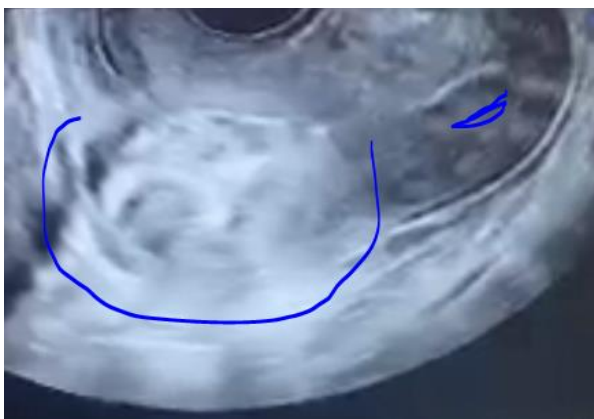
Ultrasound evaluation first at the clinic with sac in the lower segment at the site of the scar.
